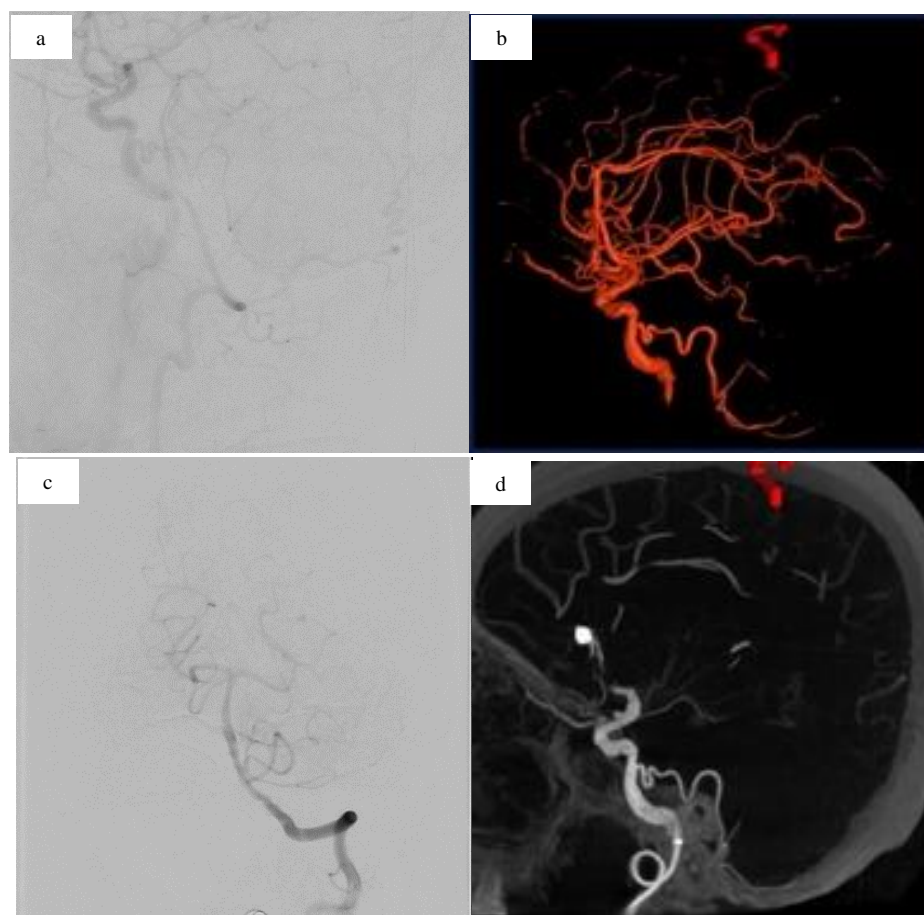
a) Lateral digital subtraction angiography (DSA) image of right internal carotid artery (ICA) showing right posterior inferior cerebellar artery (PICA) arising anomalously from a cavernous segment of right ICA, absent vertebral origin; b) Three-dimensional (3D) rotational reconstruction confirming PICA origin from ICA; c) DSA of the left vertebral artery demonstrating a normal origin and course of the left PICA from V4 segment of vertebral artery; d) Computed tomography (CT) angiogram showing coiled distal anterior cerebral artery (DACA) aneurysm and PICA arising from ICA
